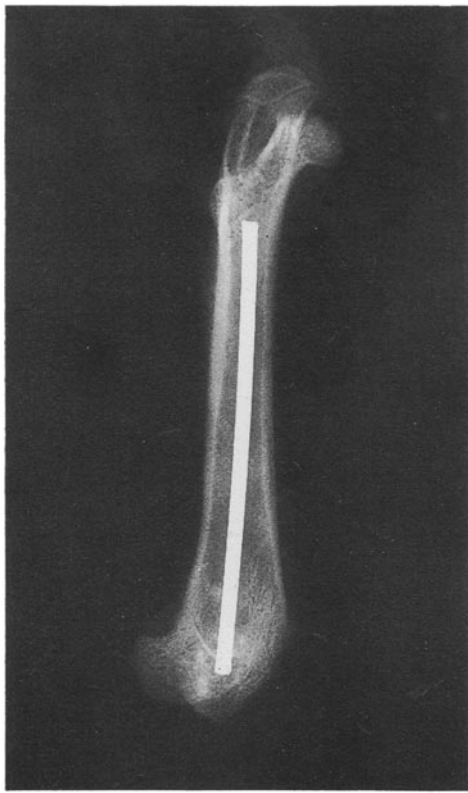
X-ray of the femur with intramedullary pin.
